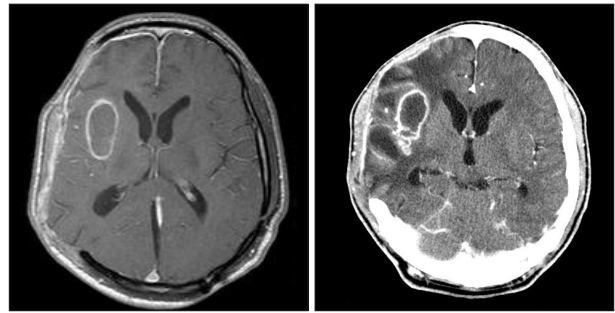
Gadolinium enhanced magnetic resonance image and contrast enhanced CT taken 35 days later show an increase in both the size and extent of the brain abscess.
